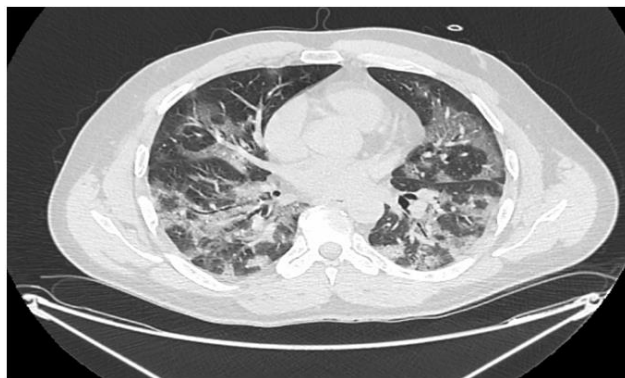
10.08.2020 CT scan of the chest showing bilateral ground glass opacities
